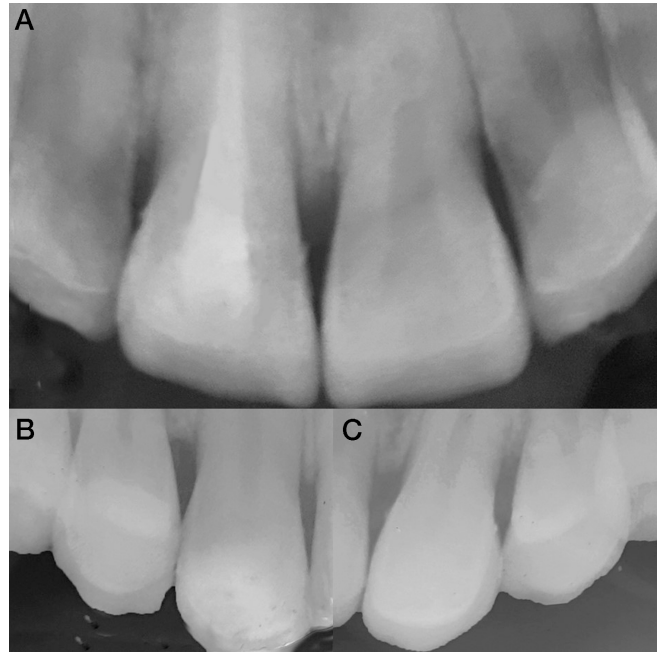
Postoperative X-ray photos of restorations 4 years after cementation. (A): Front view. (B): Side view (right). (C): Side view (left).
